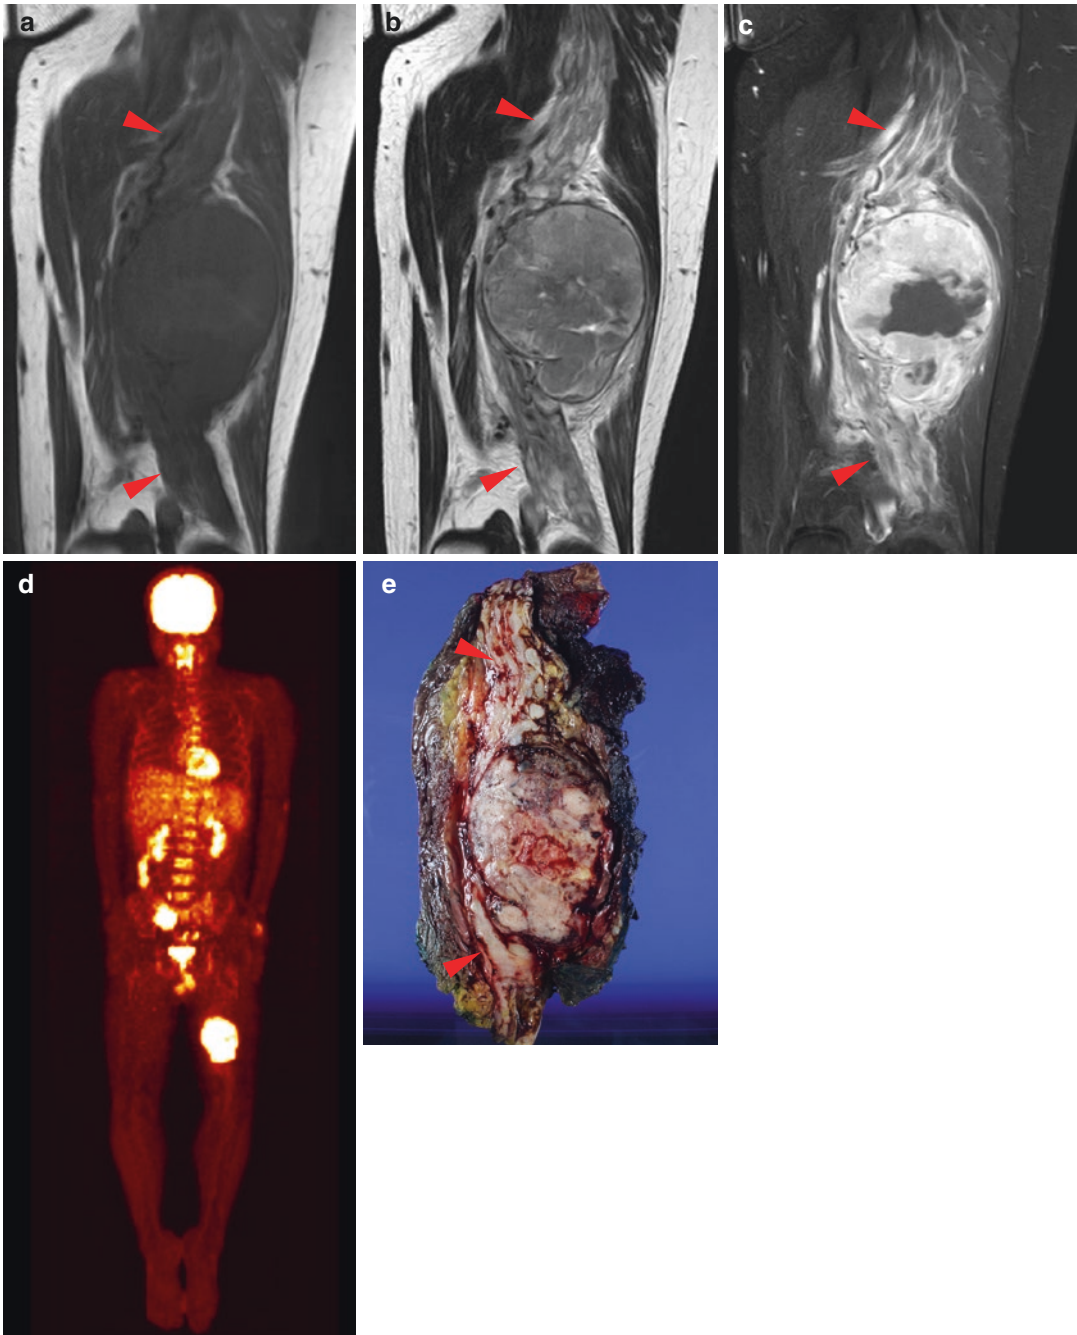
Malignant peripheral nerve sheath tumor. Coronal MR images of the thigh in a patient with NF-1 show a diffuse thickened and nodular sciatic nerve with a “bag of worms” appearance (*arrowheads*), representing plexiform neurofibroma. The large mass eccentric to the sciatic nerve is depicted with inhomogeneous isointense signal (to muscle) on T1WI (a), heterogeneous signal (ranging from hypo- to hyperintensity) on T2WI (b), and heterogeneous intense enhancement on postcontrast FS
